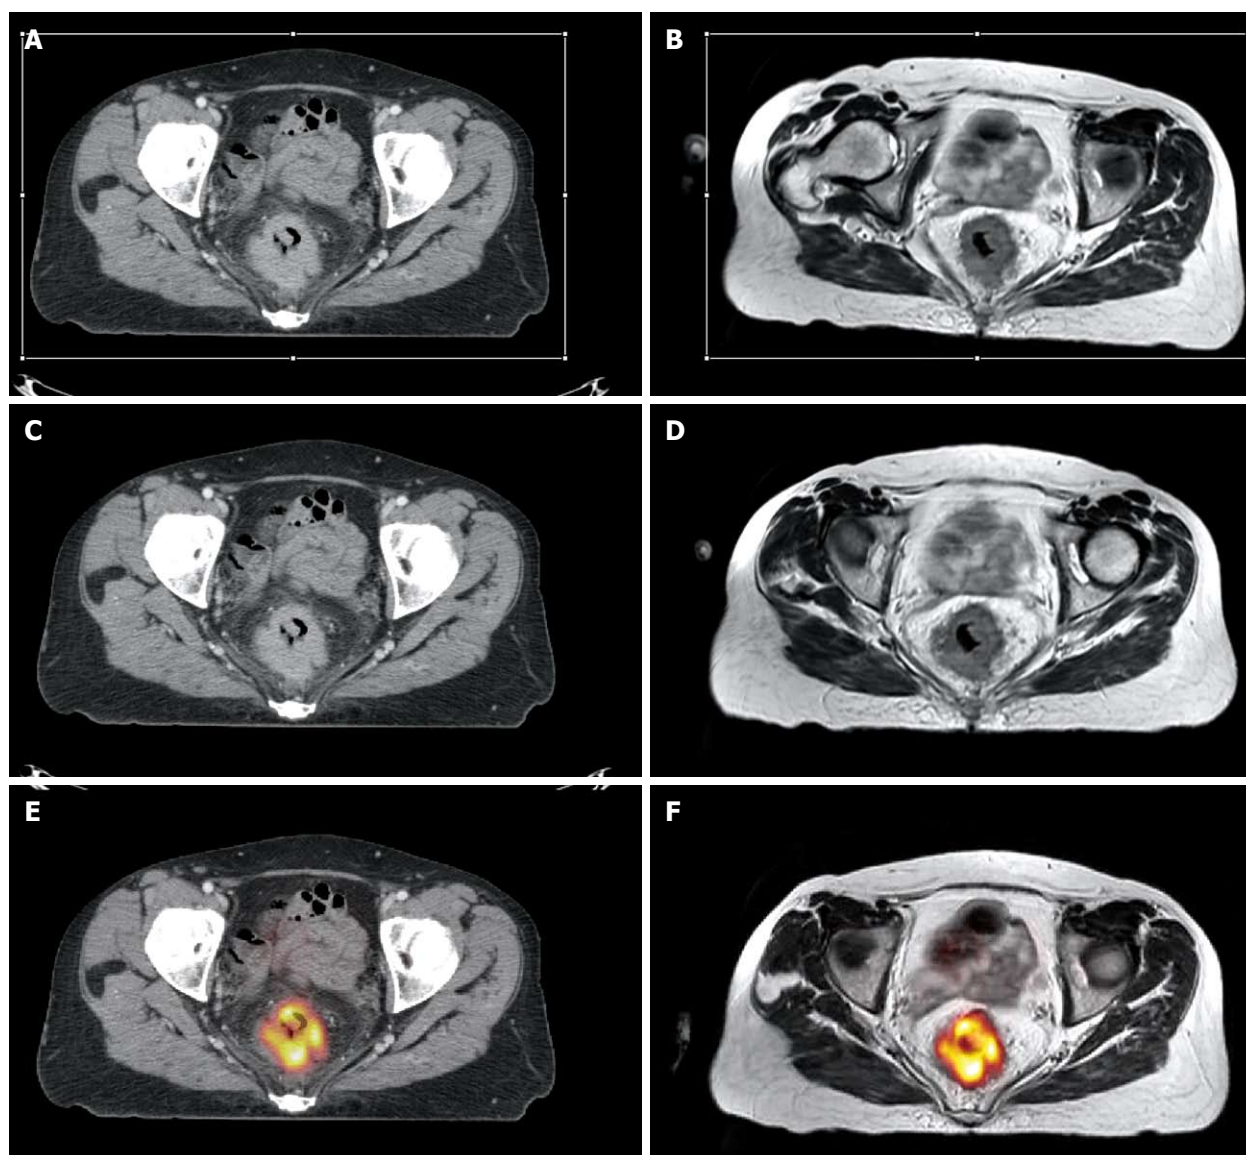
Multimodal image registration can be performed to improve staging and radiotherapy planning of rectal cancer. Axial contrast enhanced computed tomography (CT) at the portal phase (A) and rigid registration of the axial T2w magnetic resonance (MR) image (B). Rigid registration reduces the misalignment between the anatomical structures in the two modalities. A, B: Volume selection (rectangular white thin line) for non-rigid registration is performed; C, D: Non-rigid registration compensates for the more complex deformations due to the different acquisition setting; E, F: Following non rigid registration, MR can be fused with the positron emission tomography (PET) image (F) and the result is super-imposable on the PET-CT image (E).
